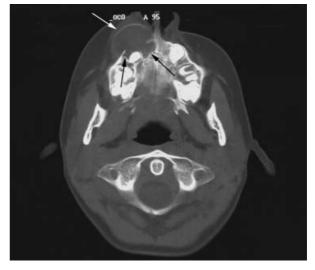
Computed tomography scan of case 2 showing a cystic expansile lesion in the right maxilla that is expanding labially with well-defined margins.
